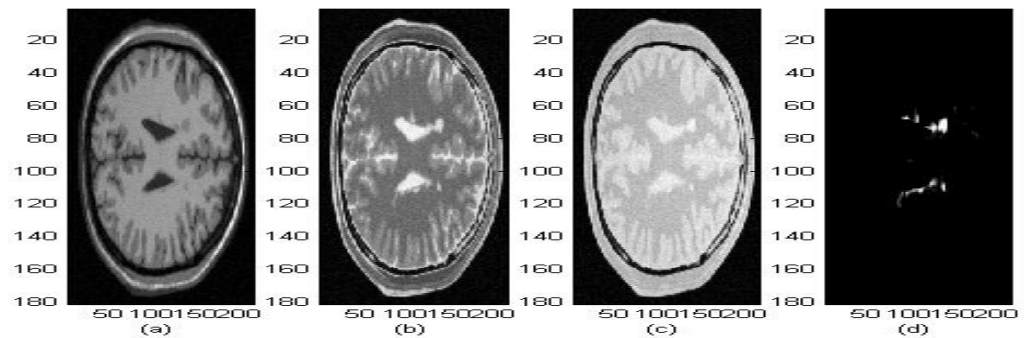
(a) T1 weighted (B) T2 weighted (c) PD (d) Target MRI images
